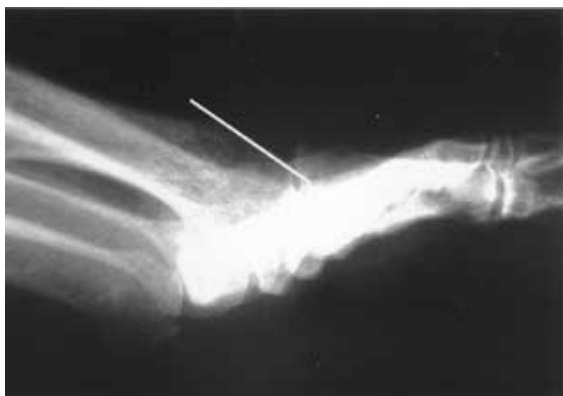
Postoperative lateral radiograph following cheilectomy. The resection surface (white line) is angled slightly in a plantar direction relative to the dorsal surface of the first metatarsal diaphysis.
